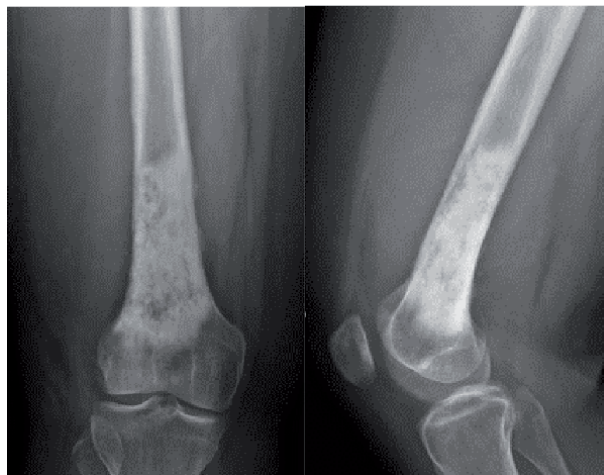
Radiographic images of a patient with a distal femur conventional, central, osteoblastic, high grade osteosarcoma. The tumor presents a mixed, blastic and lytic, moth-eaten pattern.
